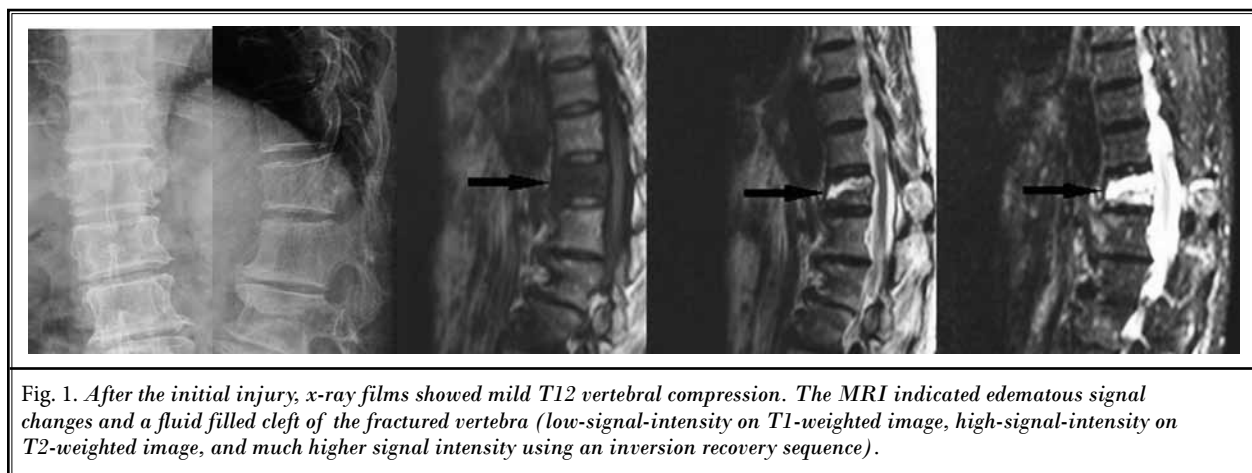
After the initial injury, x-ray films showed mild T12 vertebral compression. The MRI indicated edematous signal changes and a fluid filled cleft of the fractured vertebra (low-signal-intensity on T1-weighted image, high-signal-intensity on T2-weighted image, and much higher signal intensity using an inversion recovery sequence).
